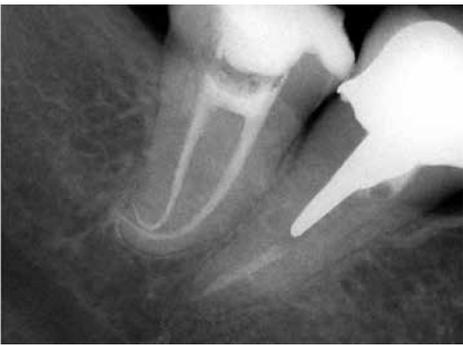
A postoperative radiograph of a lower third molar with severely dilacerated canals. The mesial and distal canals were prepared with files X1 and X2 only. The canals were obturated with Thermofil® (Courtesy of Dr. Giuseppe Cantatore, Milano, Italy)
